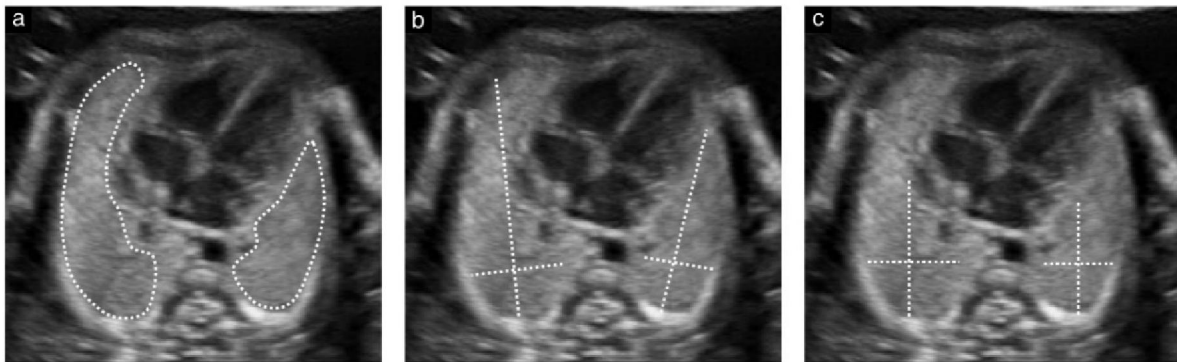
Two-dimensional ultrasound images showing measurement of the lung area in the cross-sectional plane of the thorax (used for examination of the four-chamber view of the heart) (a) by manual tracing of the limits of the lungs, (b) by multiplication of the longest diameter of the lung by its longest perpendicular diameter, and (c) by multiplication of the anteroposterior diameter of the lung at the mid-clavicular line by the perpendicular diameter at the midpoint of the anteroposterior diameter (Peralta et al., 2005).
